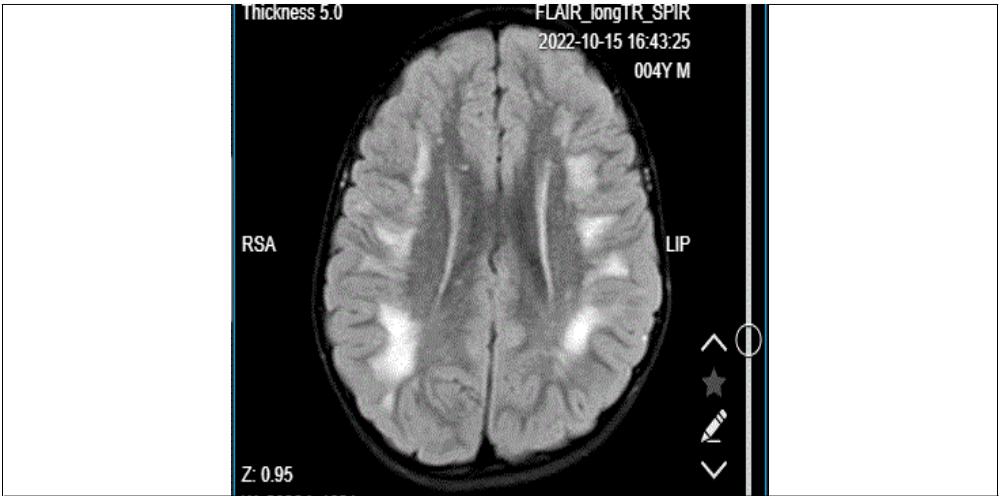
Axial FLAIR MRI showing bilateral symmetrical confluent deep white matter hyperintensities
